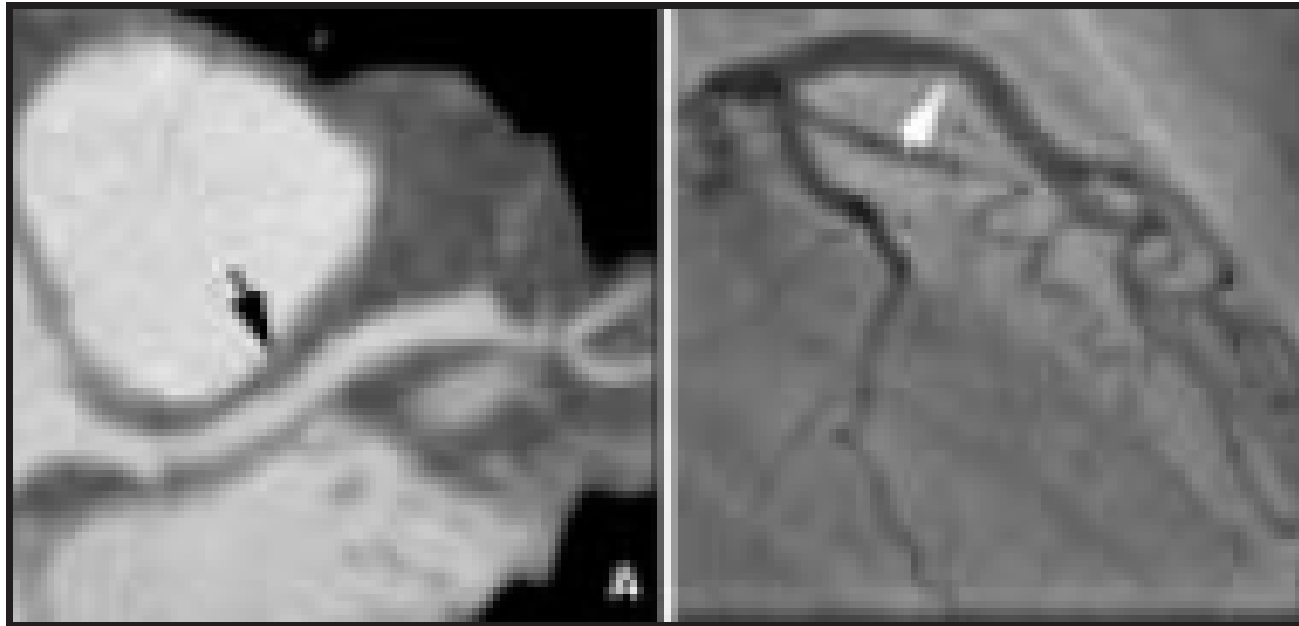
CTA (A) and invasive coronary angiogram (B) of a 33-year-old woman with strong family history of coronary artery disease. The plaque seen on the CTA (black arrow) could easily have been missed on the invasive angiogram (white arrow).
